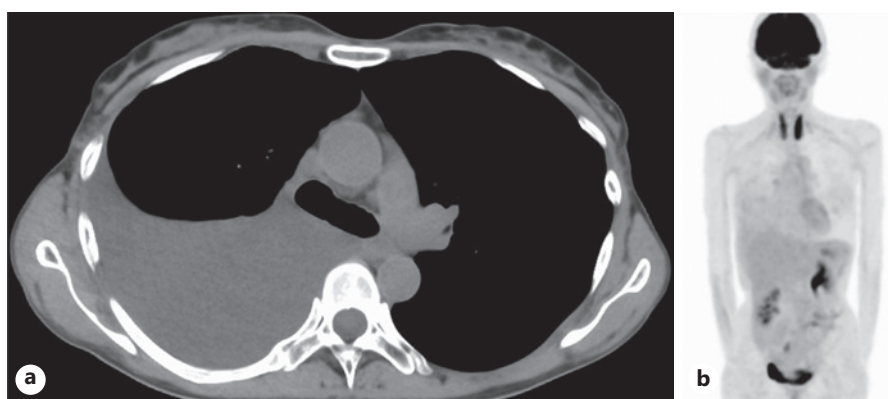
Chest computed tomography (CT) and positron emission tomography (PET). a CT showed massive effusion in the right pleural cavity, neither with pulmonary nodules nor with pleural masses. b PET showed no avidity in the breasts.
